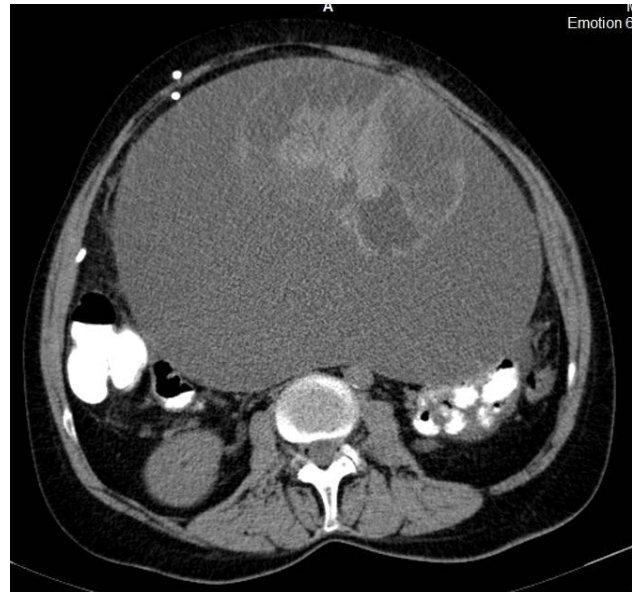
CT scan transverse section of the abdomen. Massive tumor occupying most of the abdomen. Multiple cysts can be observed inside.
